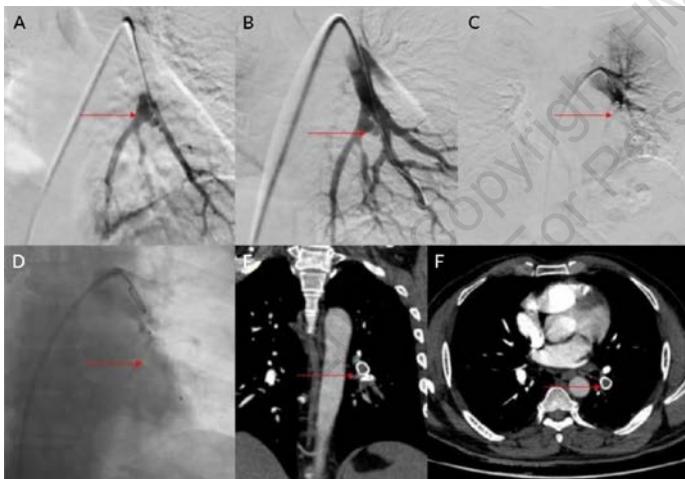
Amplatzer plug (Abbott) placement. (A) and (B) Left descending pulmonary artery angiogram showing an aneurysm involving the superior and lateral branches. (C) and (D) Amplatzer plug placement within the descending pulmonary artery and post embolization angiogram showing non-opacification of the aneurysm. (E) and (F) Follow-up contrast-enhancing computed tomography chest showing non-opacification of the aneurysm and the left descending pulmonary artery with plug in situ.
